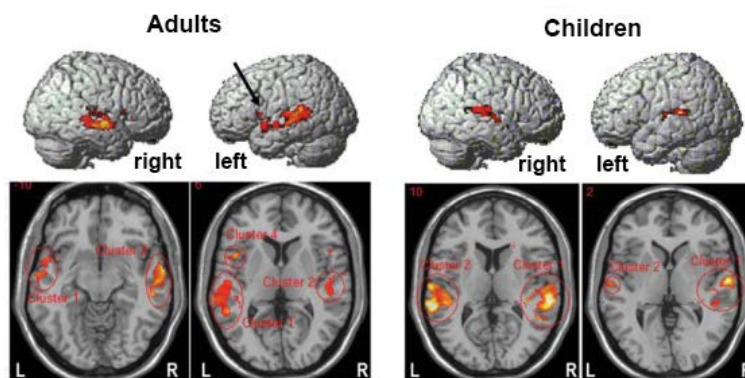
Clusters for the DLT in adults (n=11) and in children (n=6) on selected axial T1-weighted images and the lateral view of the brain. Result of second-level analysis. Adults (left side): in the left hemisphere, the largest of the clusters present was located in the STG, with extensions running to the end of the temporal cortex and the insula (clusters 1 and 4), one smaller cluster was detected in the IFG (arrow, left lateral view). In the right hemisphere, the cluster was located in the MTG and STG (cluster 2). Children (right side): 2 clusters were found (clusters 1 and 2), one in the left STG, the other in the right STG.⁴
